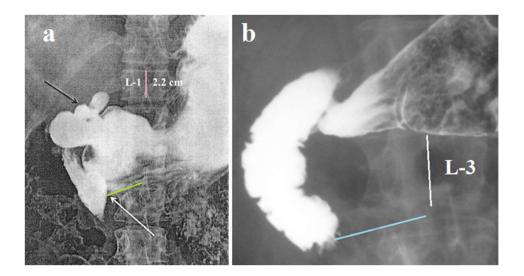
Radiographs of patients with duodenal dyskinesia. (a) Case described as superior mesenteric artery syndrome. The black arrow shows an ulcer in the duodenal bulb. White arrow shows the beginning of the narrowing in the third part of the duodenum, which is regarded as compressing the duodenum in the aorto-mesenteric angle. The pink line corresponds to the height of the 1st lumbar vertebra, which in adults is 2.2 cm. Consequently, the beginning of the narrowing of the duodenum is at a distance of 3 cm from the aorta. (b) There is zone of contraction of the duodenum, which begins 3.2 cm from the midline of the vertebra. The other sphincters (pyloric, post-bulbar, and Kapanji) have not contracted.
